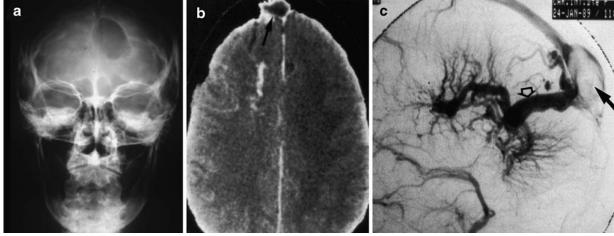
SP on plain skull radiograph (a), contrast-enhanced CT scan (b) and DSA (c). The radiograph (a) demonstrates the bony defect on the midline, the CT scan (b) demonstrates a DVA in close spatial relationship to the SP (*black arrow*), and the angiogram (c)
